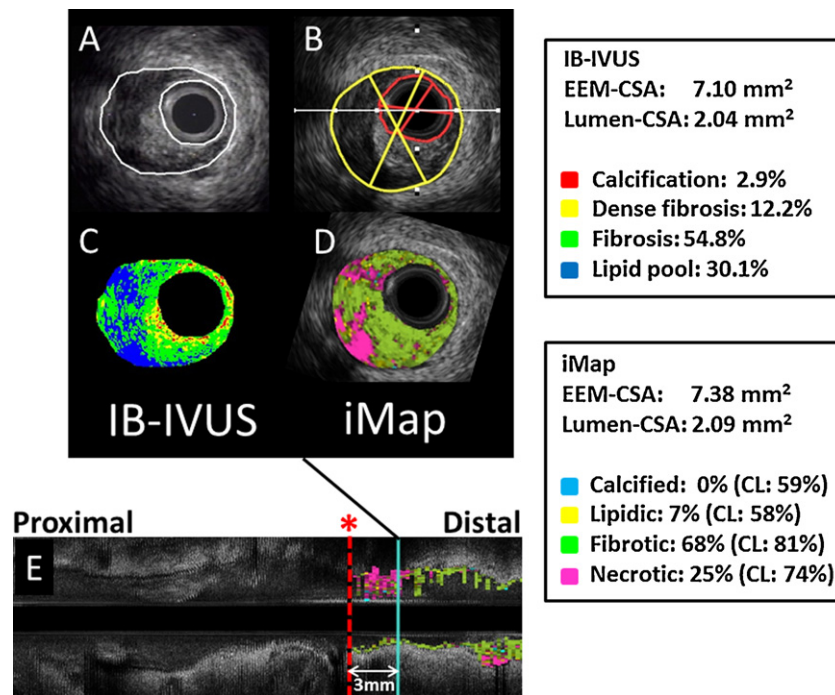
Representative images obtained by using integrated backscatter-intravascular ultrasound (IB-IVUS) and iMap. Both IVUS images were carefully selected at 3 mm distal from the branch (*) and compared. The images shown are as follows: (A) gray scale image (IB-IVUS); (B) gray scale image (iMap); (C) color-coded image (IB-IVUS); (D) color-coded image (iMap); (E) longitudinally reconstructed IVUS image. EEM, external elastic membrane; CSA, cross-sectional area. (For interpretation of the references to color in this figure legend, the reader is referred to the web version of this article.)
